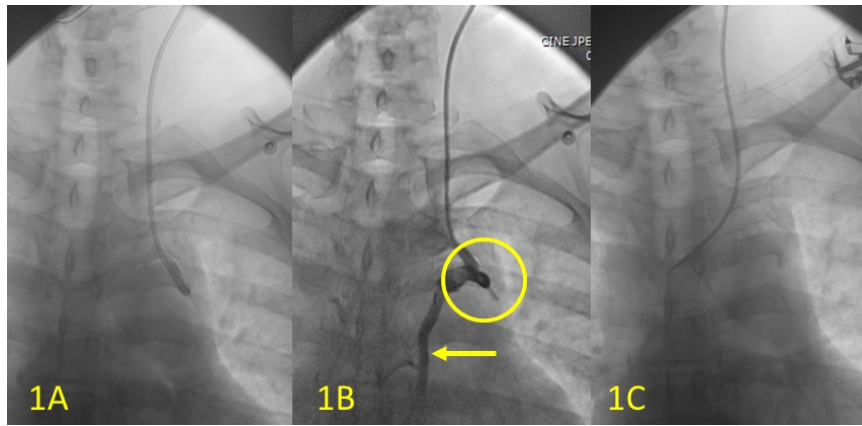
1A: Chest X-ray AP view showing central venous catheter tip not taking the course from left internal jugular vein to superior vena cava. 1B: shows contrast distribution through the central venous line into the internal mammary vein (Arrow) and the indentation of the catheter on the wall of the vein (circle). 1C: image during repositioning, showing the catheter taking a proper course
